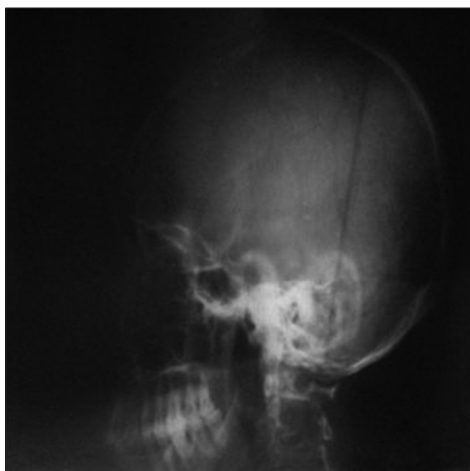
Skull X-ray free of “punched out” lesions
